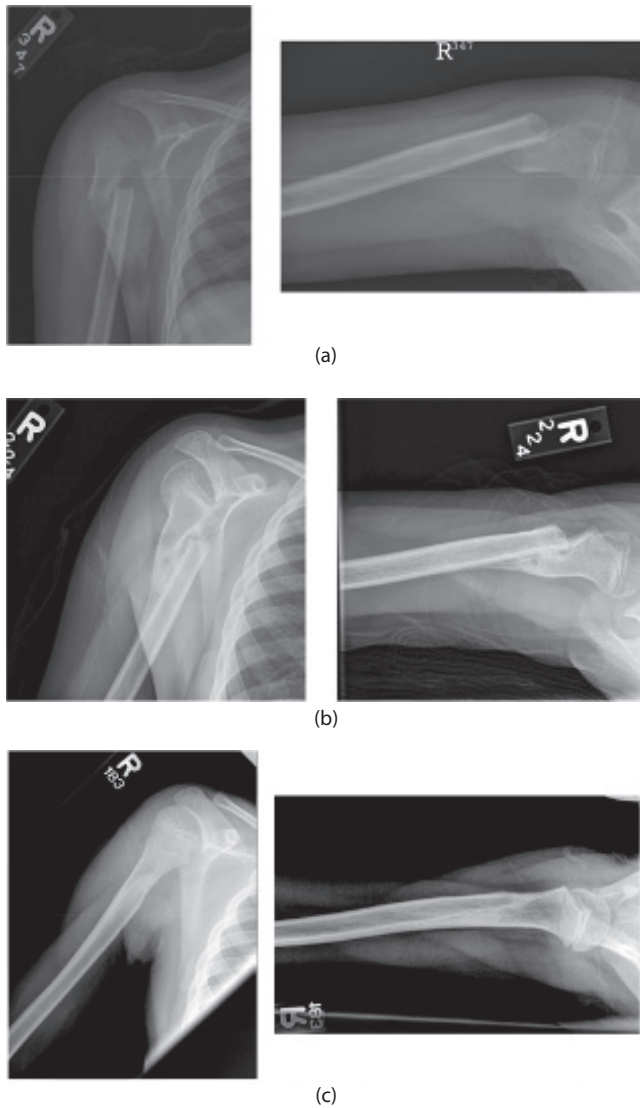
Radiographs showing a proximal humerus fracture in a 9-year-old patient at: (a) initial injury, (b) 6 weeks after injury, and (c) 9 months after injury. As demonstrated, proximal humerus fractures in children have a significant potential to remodel.
